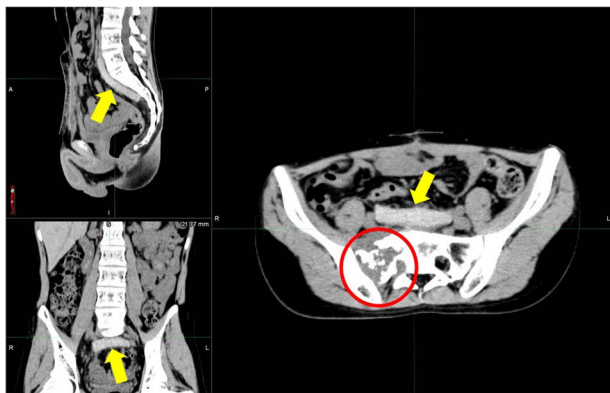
Clinical application of PGA spacers. CT image of a 14-year-old boy with a primary Ewing-like tumor in the sacrum, a case of recurrence (circle) after previous proton therapy in the primary sacrum. A PGA spacer (arrow) was implanted to reduce the dose irradiated to the gastrointestinal tract as much as possible during re-proton therapy with irinotecan and CPA chemotherapy combination. PGA, polyglycolic acid; CT, computed tomography; CPA, cyclophosphamide.
